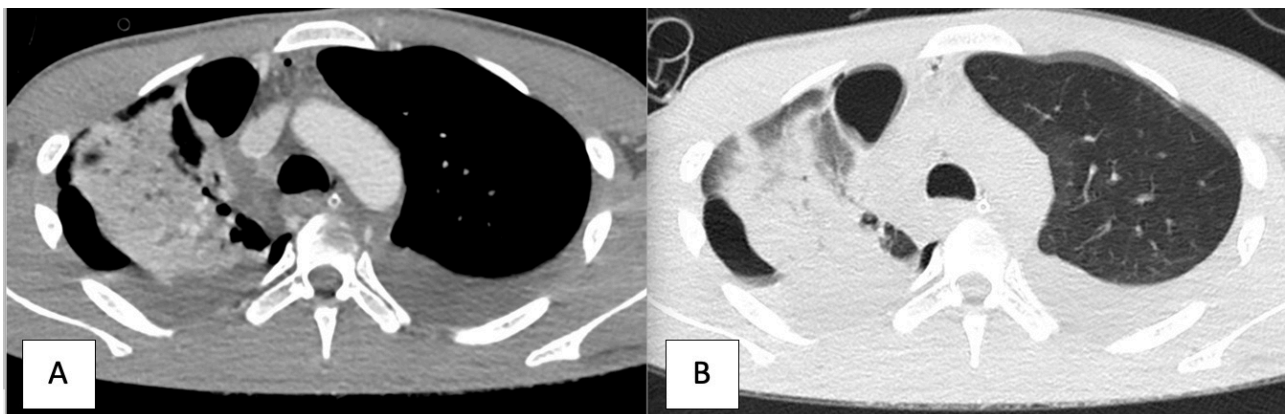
Axial contrast CT Thorax (A and B) in soft tissue and lung window demonstrates right pneumothorax, bilateral haemothorax and right lung contusion.
